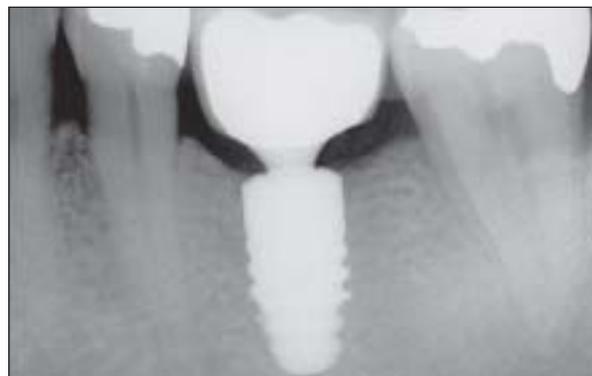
Radiographic examination of cortical bone position after 6 months.
